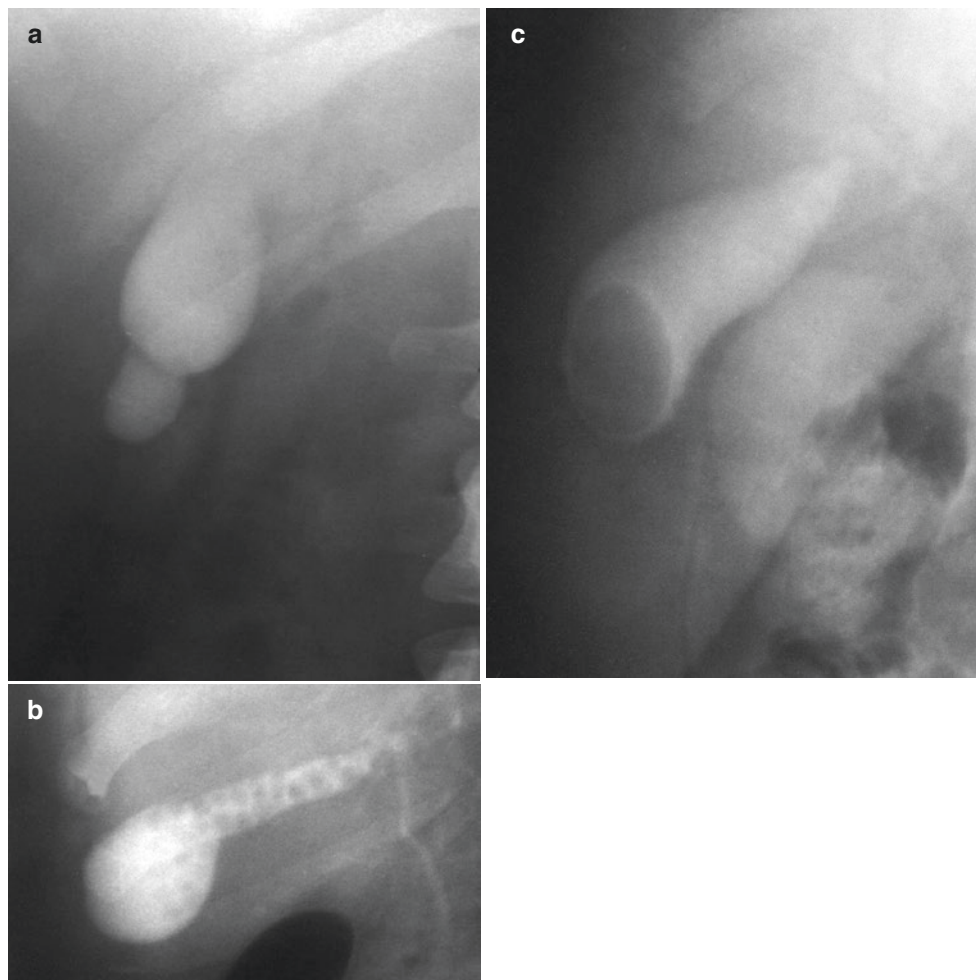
(a) Large solitary gallstone seen on X-ray in gallbladder. (b) Multiple stones seen in gallbladder during cholecystography, (c) Preoperative cholecystogram outlining the normal anatomy of the gallbladder, cystic duct, hepatic ducts and the common bile duct with dye
